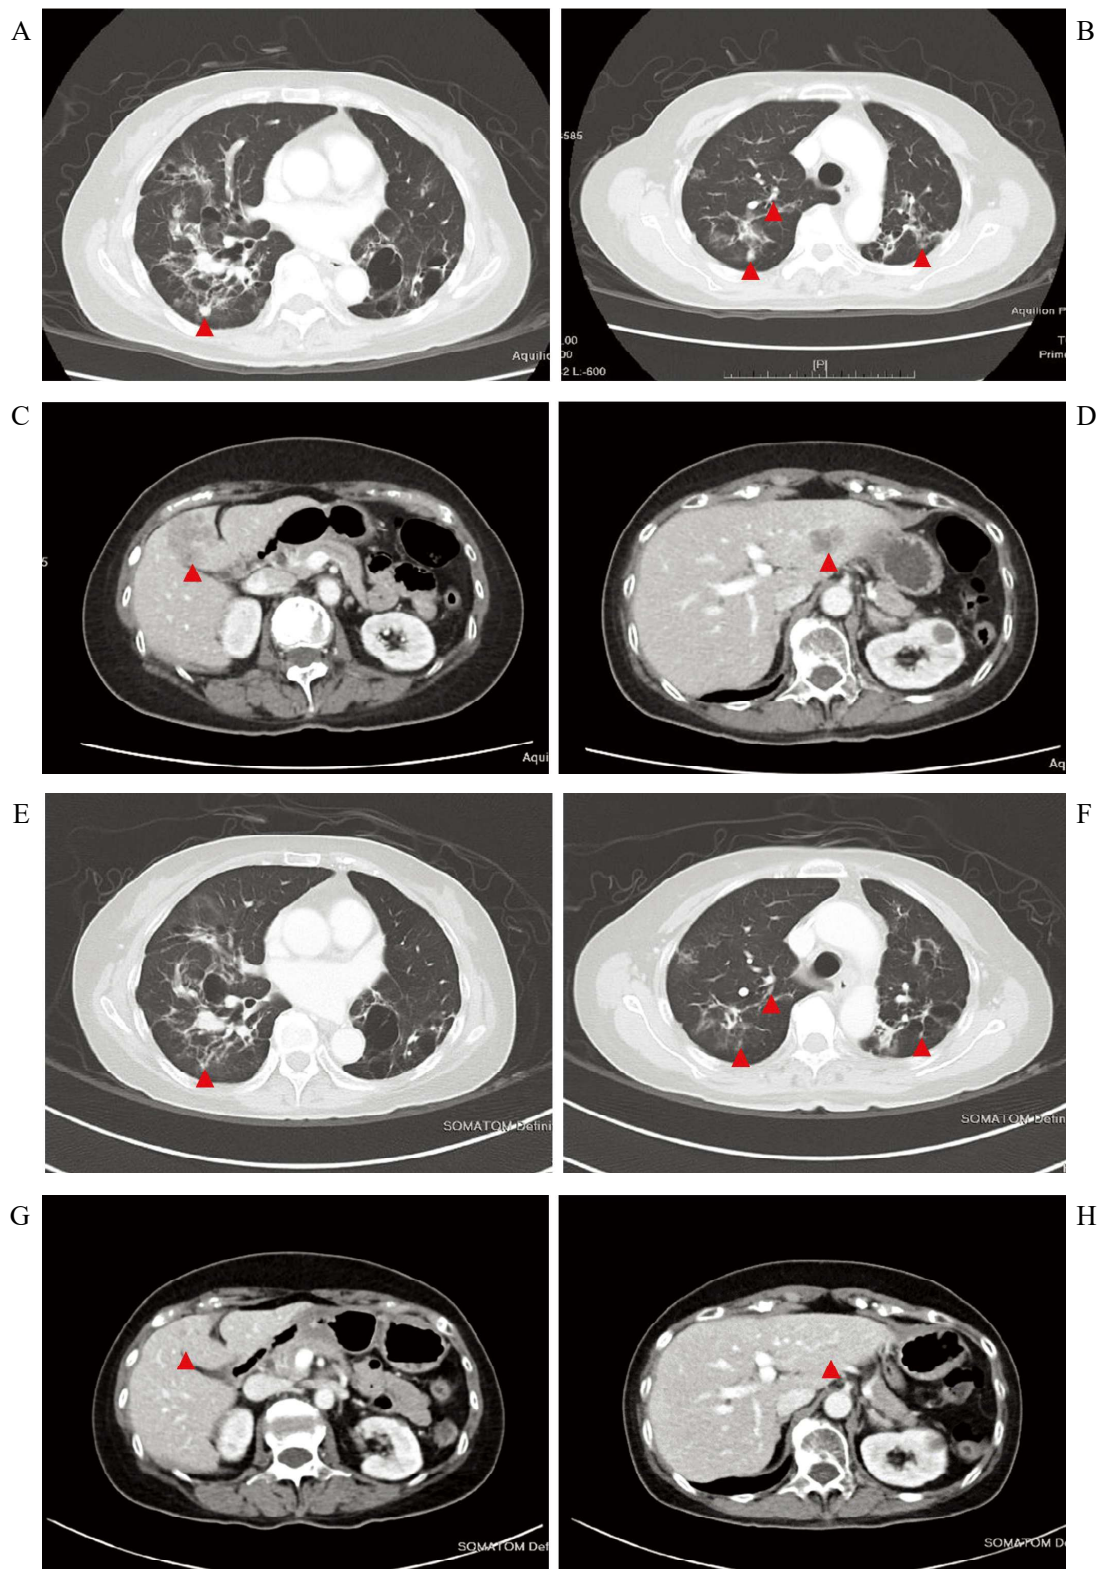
Chest CT scans before and after dacomitinib treatment of a female patient who received multiple treatments, including *EGFR*-TKIs, chemotherapy and immunotherapy.
